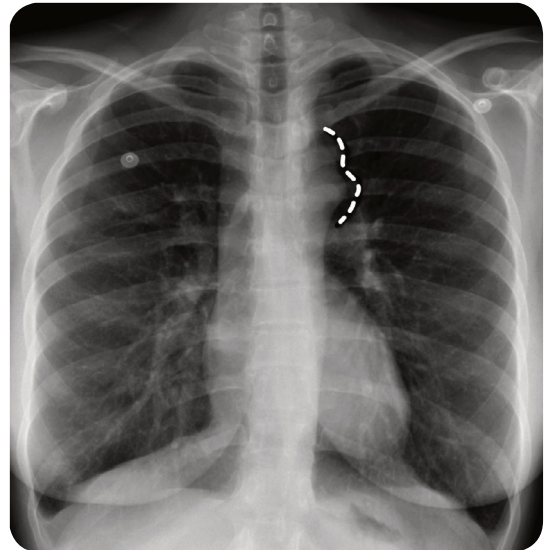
A chest radiograph demonstrating the figure of three sign seen in coarctation of the aorta.
